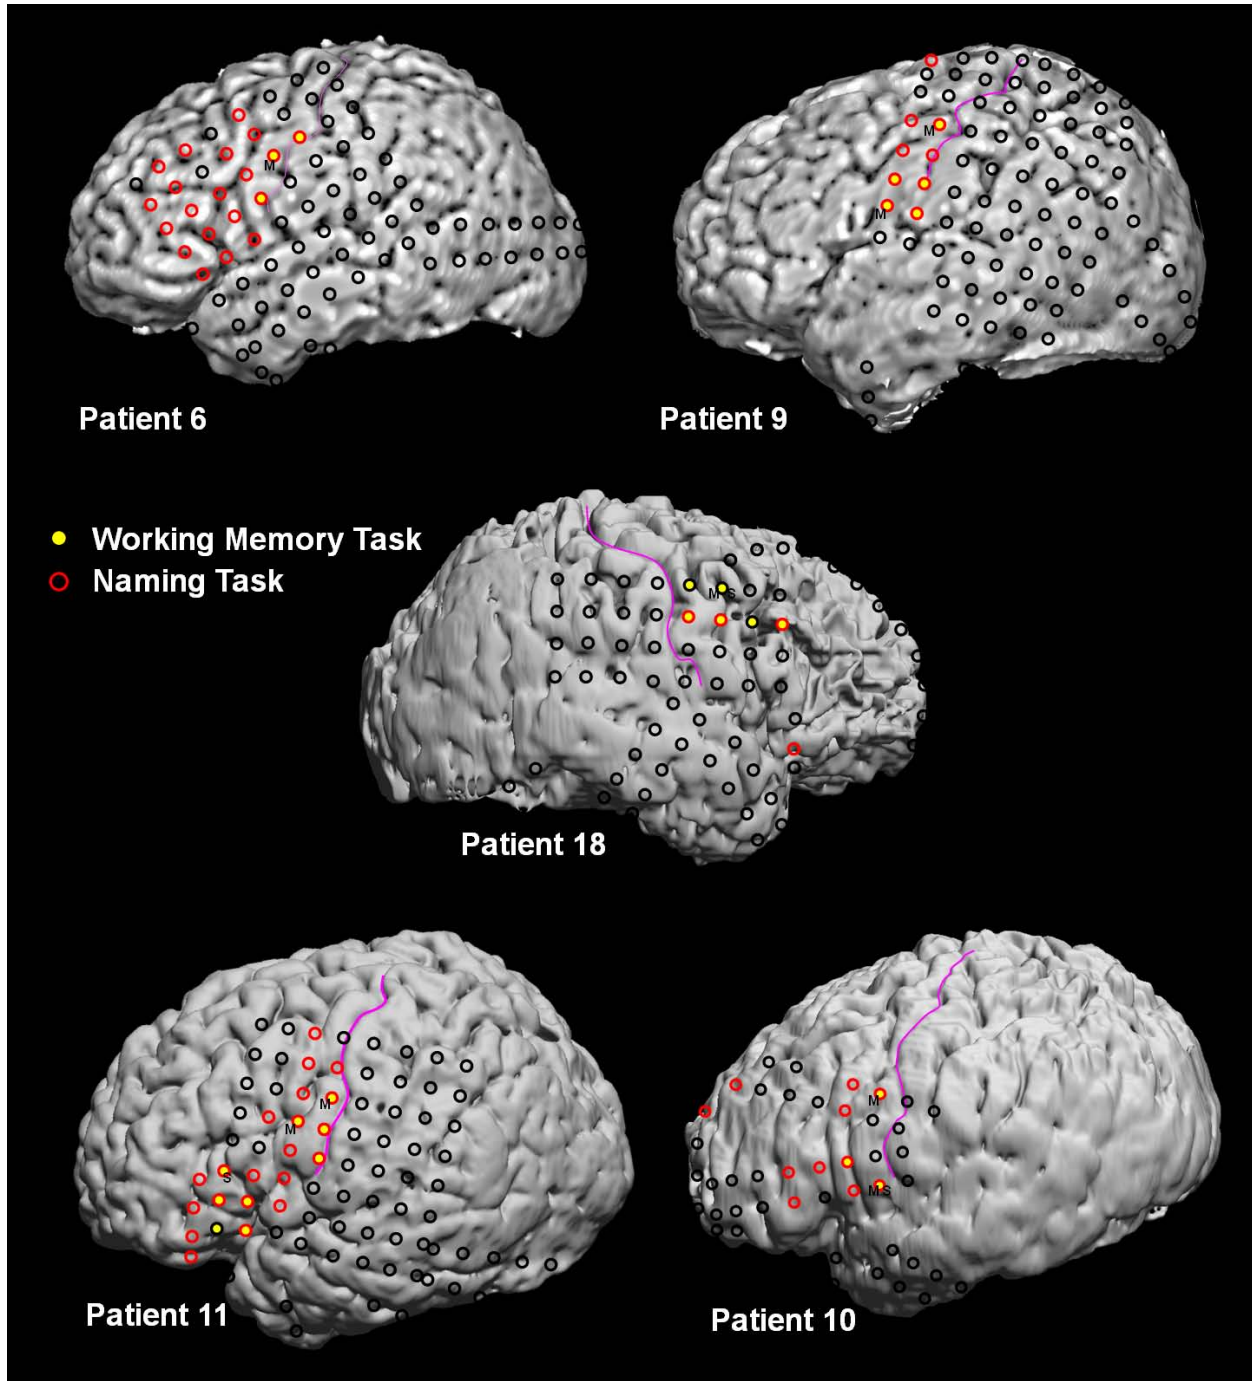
Working Memory and Naming Sites. Displayed are the MRI images of the brains of the 5 patients with working memory maintenance function observed over the precentral gyrus or sulcus. Working memory maintenance is identified by the letter 'M' near a red-yellow electrode; 'S' for scanning. Interestingly most maintenance sites cluster midway up the precentral gyrus.
